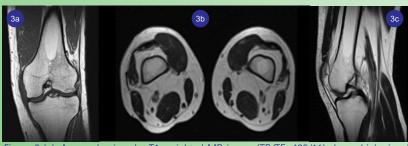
(a): Acoronal spin-echo T1-weighted MR image (TR/TE, 400/11) shows high signal tubular intra medullary lesion in the distal femur (black arrow) with small relatively low signal in it's distal metaphyseal part (white arrow) whichis probably due to degeneration or edema in the lipoma. . The major part of the lesion consisted of areas of isosignal intensity with subcutaneous fat. (b & c) An axial and sagittal spin-ech and sagittal T2-weighted MR image (TR/TE, 2600/84) shows a hyperintense lesion iso-signal with the subcutaneous fat (black arrow).
